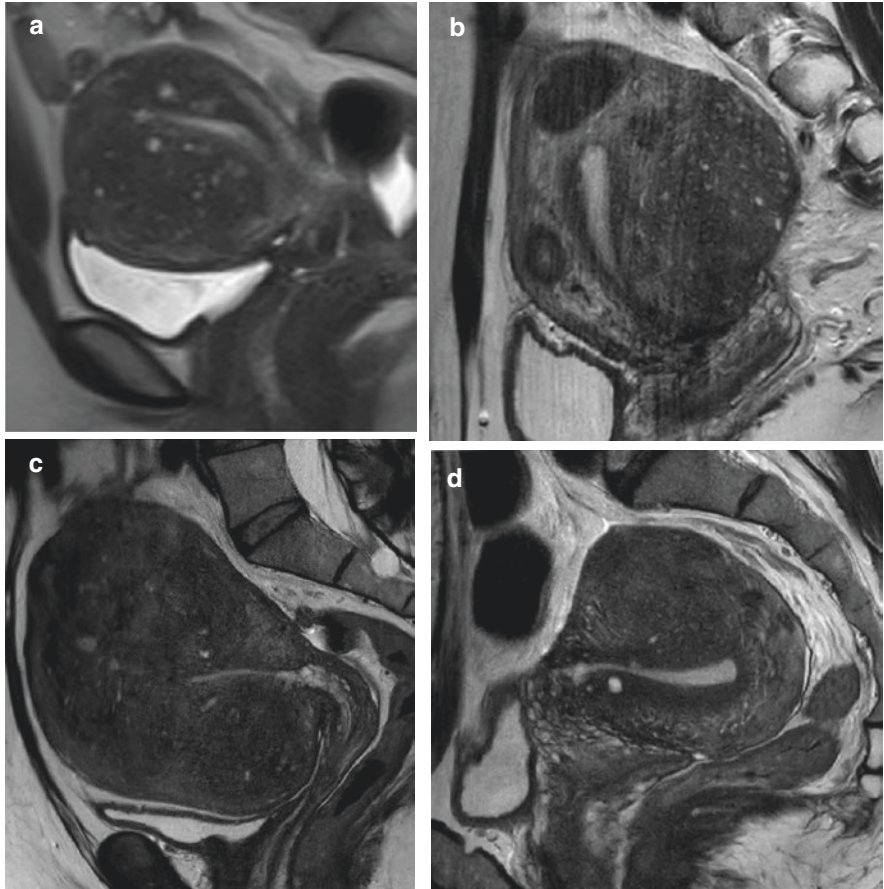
Examples of typical adenomyosis features and adenomyoma. MRI of the uterus in sagittal view, all T2W turbo spin echo. All cases show diffusely demarcated low-intensity signal areas within the myometrium, containing high-intensity signal foci and/or islets. (a) Anteverted uterus with asymmetrical thickening of the anterior wall and globular shape. The junctional zone (JZ) is no more visible and almost completely invaded by adenomyosis. (b) Adenomyoma in the posterior wall. Several well-defined fibroids with a low signal are visible, which are in contrast to the ill-defined area affected by adenomyosis. Note that the JZ is thin and quite unaffected. (c) Grossly enlarged uterus containing no fibroids, only multiple adenomyoma and diffuse adenomyosis. (d) Retroverted uterus. A large adenomyoma distorts the anterior wall. The JZ is not thickened and shows smooth outer borders. However, several high signal cysts disrupt the JZ, which is highly suggestive of adenomyosis
